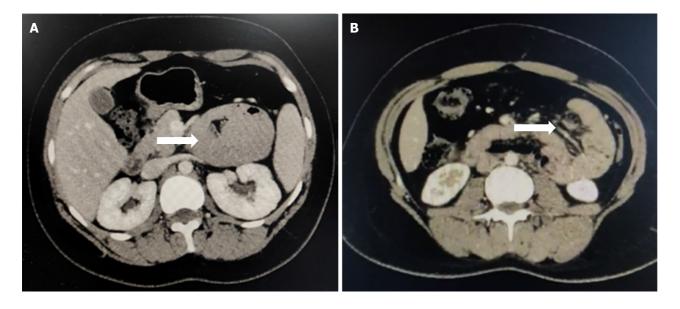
Contrast-enhanced computed tomography in a case of left paraduodenal hernia. A: Clumped-up bowel loops in left anterior renal space; B: Presence of mesenteric whirling.
